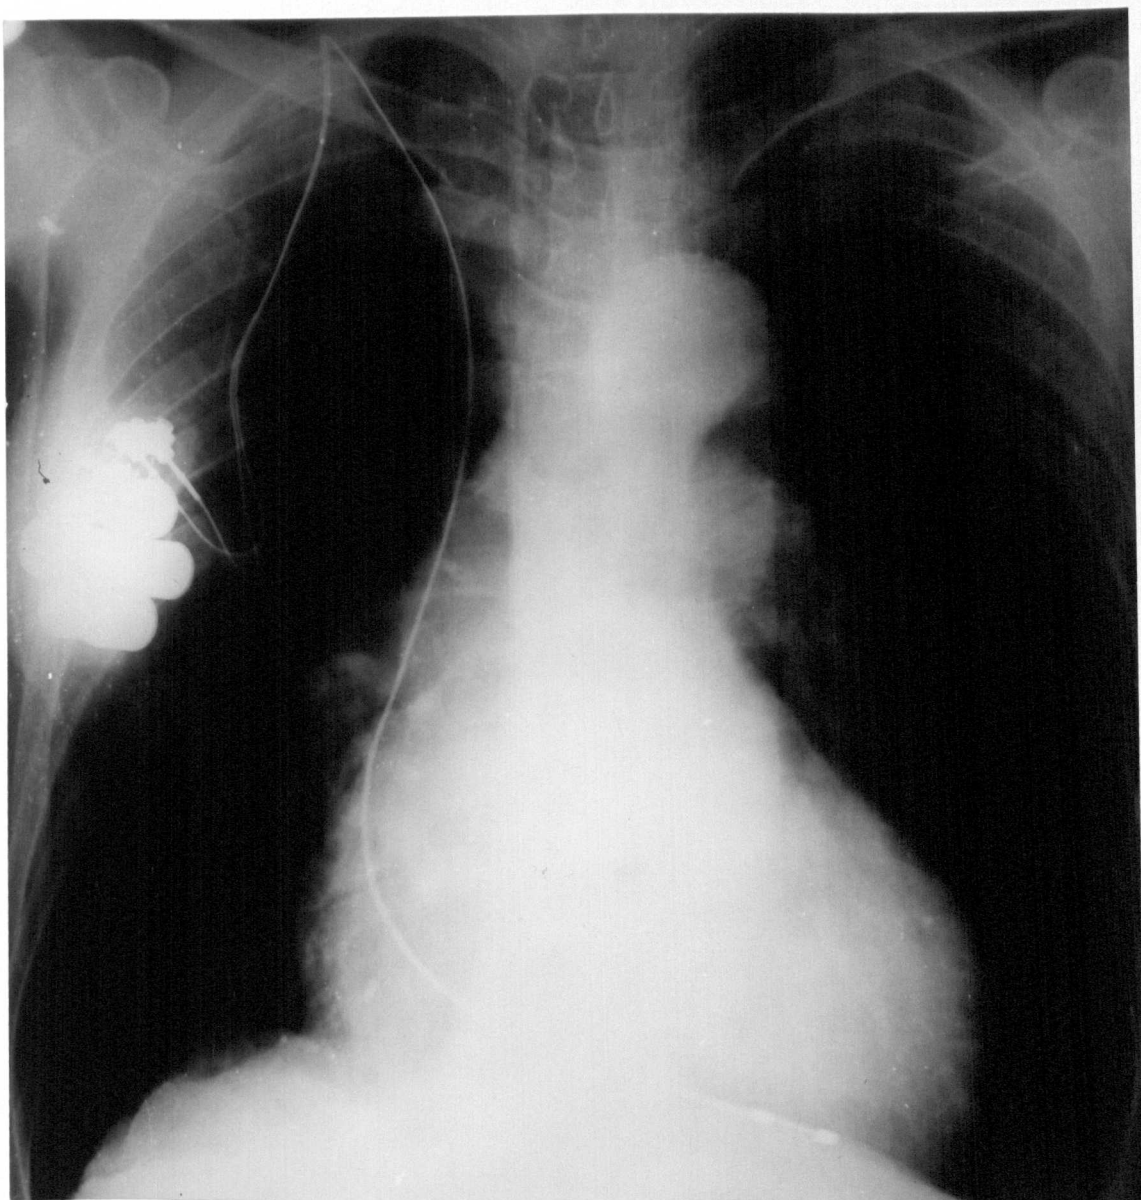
Radiograph showing the orientation of the electrodes in patient referred to in figure 52.
